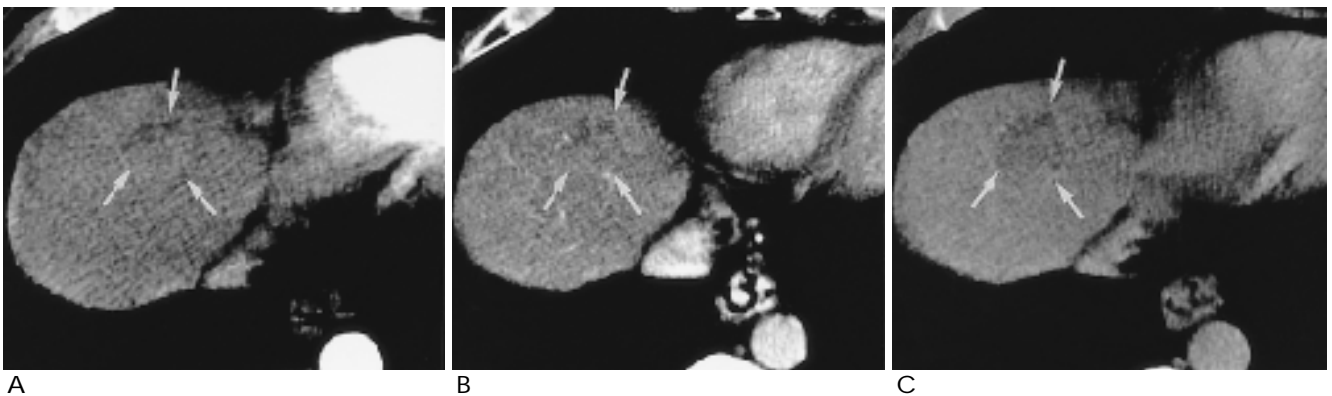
Hepatic arterial (A) and portal venous phase CT scan (B) show mixed-attenuation nodule (arrows) at liver dome. On equilibrium phase (C), nodule becomes hypo-attenuation (arrow) compared with surrounding liver parenchyma.
